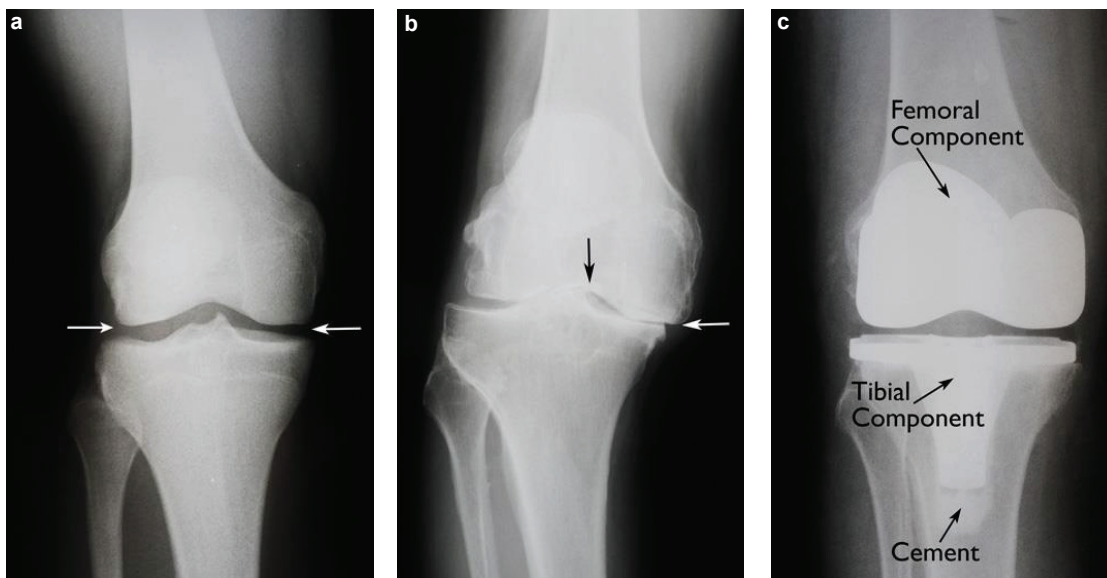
X-ray images of a knee. X-ray images of healthy (a), damaged (b) and prosthetic (c) knees. The arrows in a and b show the location of the cartilage. In c, the prosthesis re-aligns the tibia and femur similarly to a healthy knee. [138]
